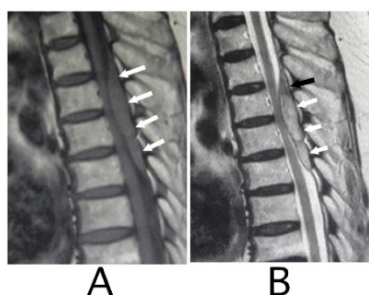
4A & 4B showing MRI features of large meningioma.
